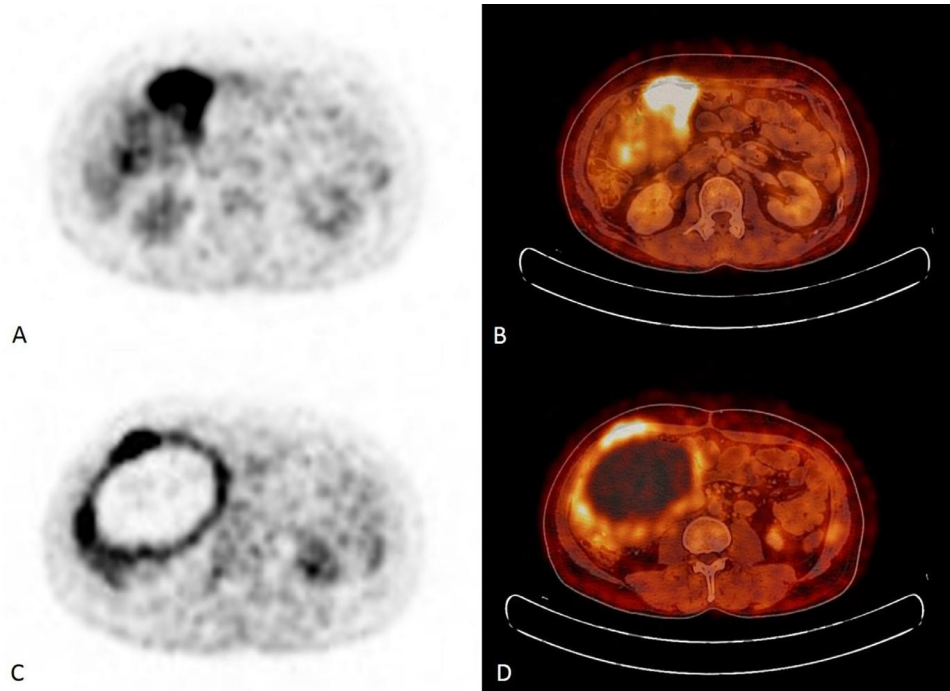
Primary malignant melanoma of the small intestine: 18FDG PET-CT shows pathologic FDG uptake in the solid component of the lesion (A, B), as well as in the margin of the lesion (C, D).
